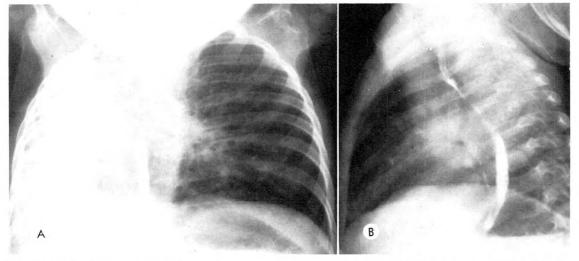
Case I. (A) Frontal esophagram showing a homogeneously dense right hemithorax. Notice that the left pulmonary artery originates in the right hemithorax. (B) Lateral roentgenogram showing posterior displacement of the esophagus and aeration of the retrosternal space.
